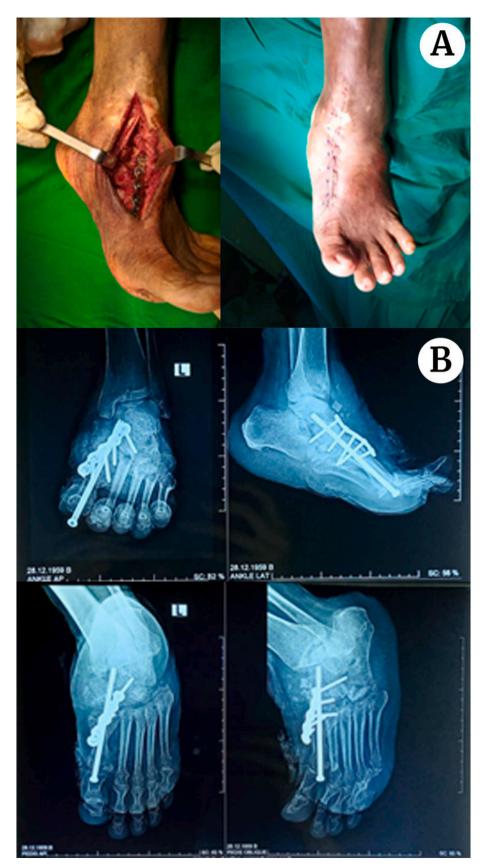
A Durante operative and post-operative X-ray of the left foot, showing reduction with intramedullary beaming and locking compression plate on the first ray.
